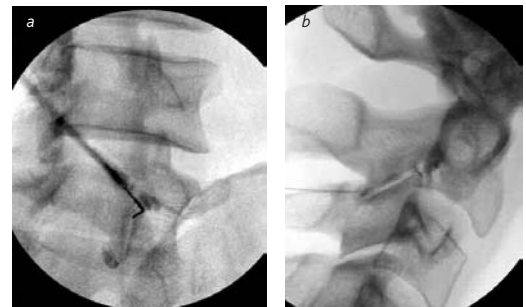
Facet joint arthrography. (a) Oblique radiograph of a lumbar facet joint arthrogram reveals intraarticular dispersal of contrast media prior to injection of therapeutic substances. Joint morphology is normal. (b) Lateral radiograph showing cervical facet joint arthrography. There is uniform dispersal of contrast media revealing normal joint morphology.
